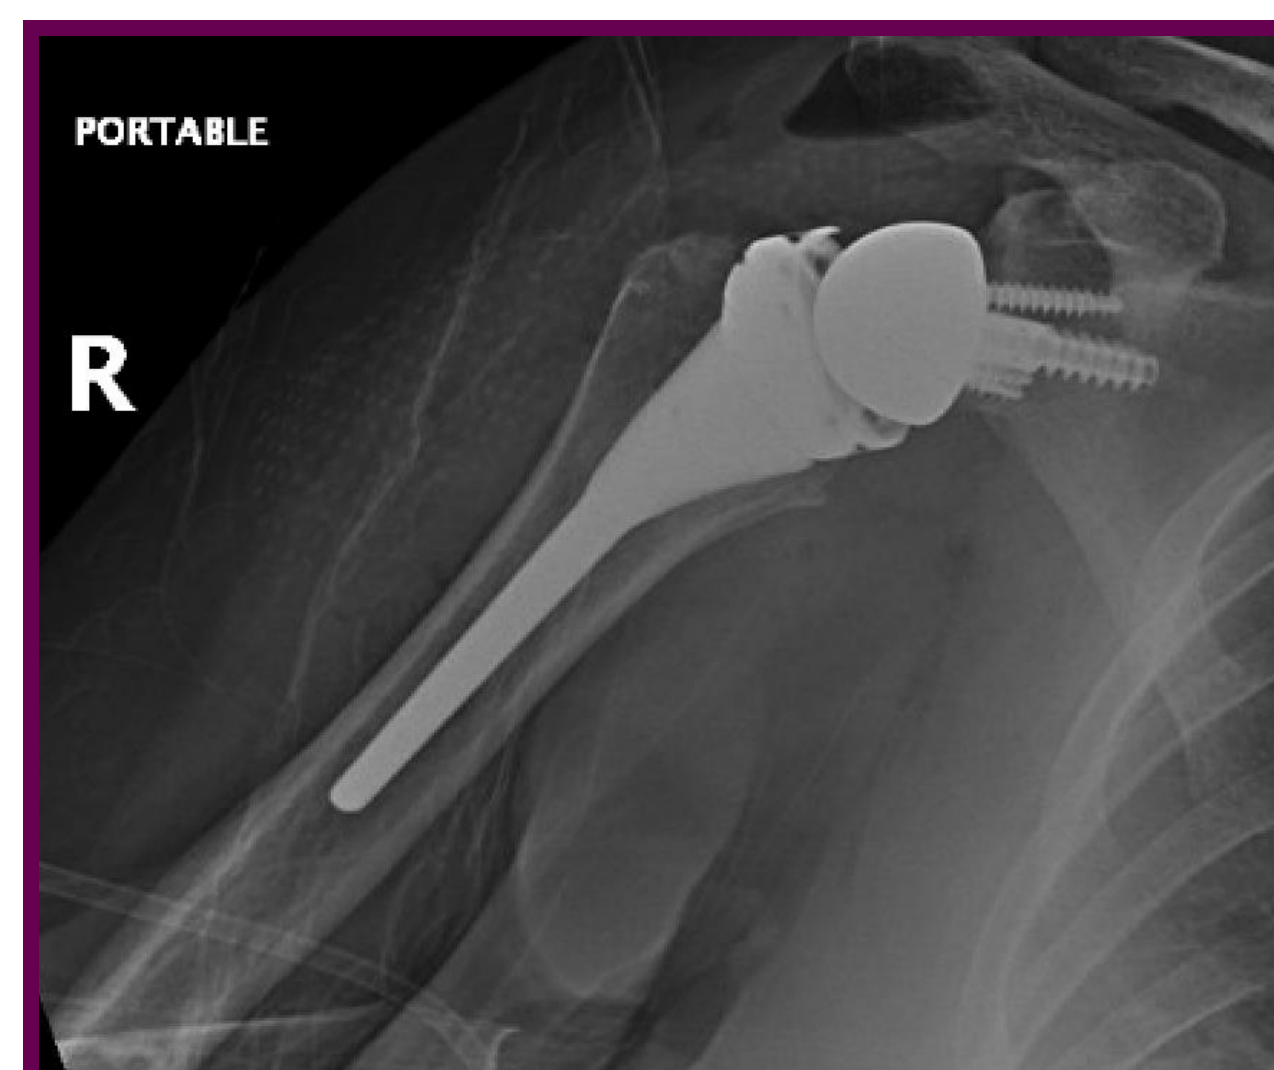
X-ray of right shoulder
